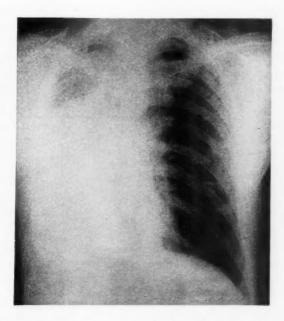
Roentgenogram made 22 days later showing extensive atelectasis of the right lung.
